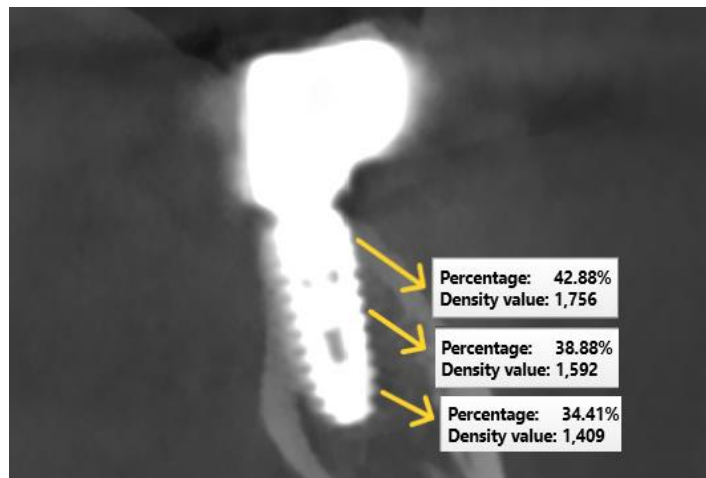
CBCT analysis for measuring density change
